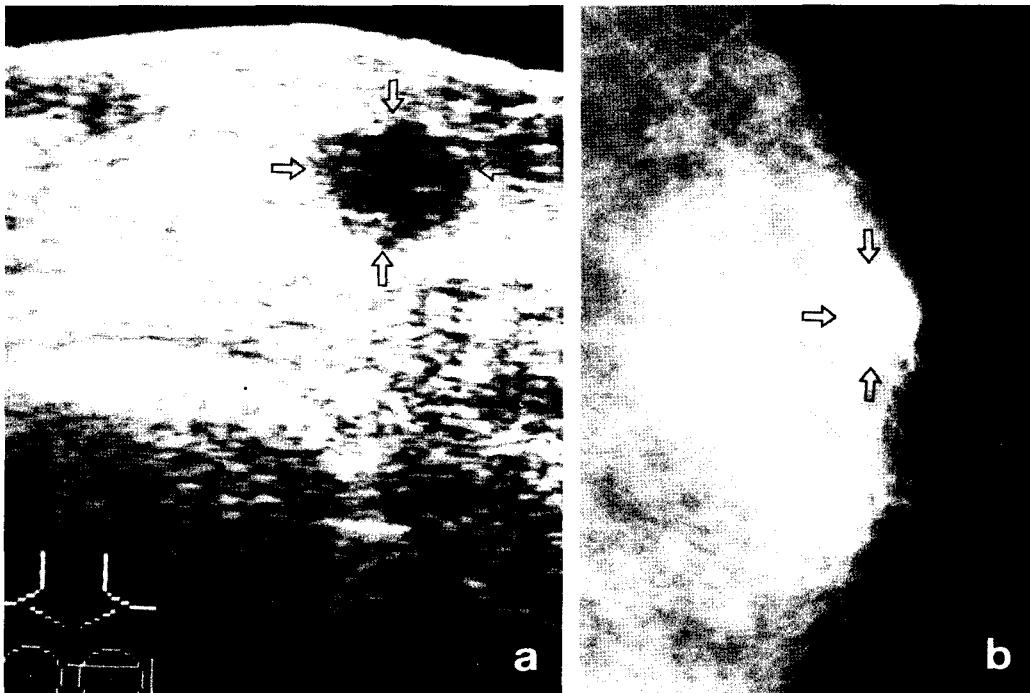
Ultrasonogram discloses a well margined hypoechoic mass (arrows) without septation or calcification (a). Mammogram shows a lobulated homogenous mass density (arrows) without vessel, duct dilatation or calcification (b).
